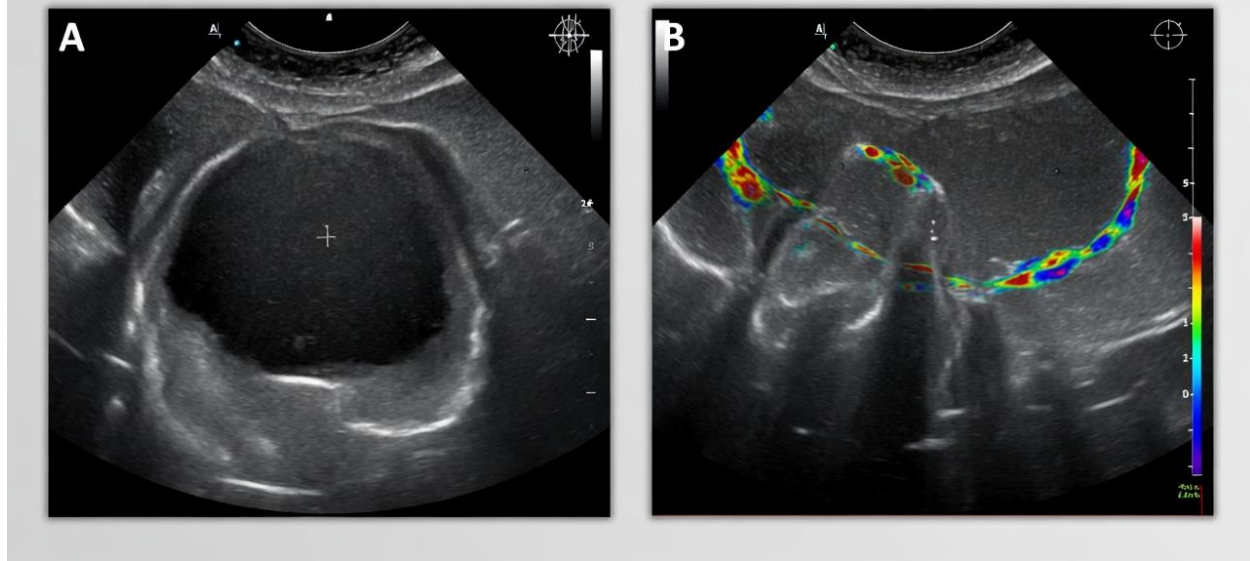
Representative high-frequency ultrasound protocol used in the study
